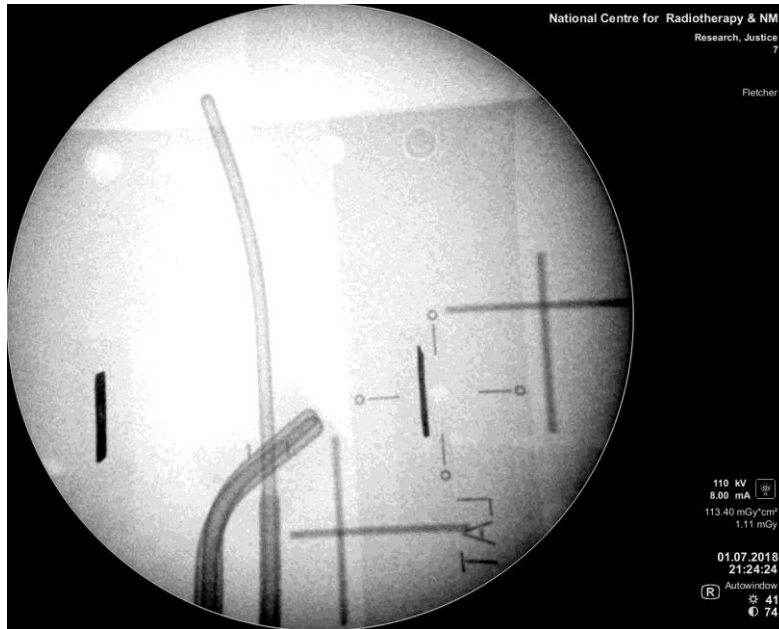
Lateral (LAT) Radiograph of the Fletcher Suite of Applicator Insertions obtained from one of the Experimental Set-Ups
